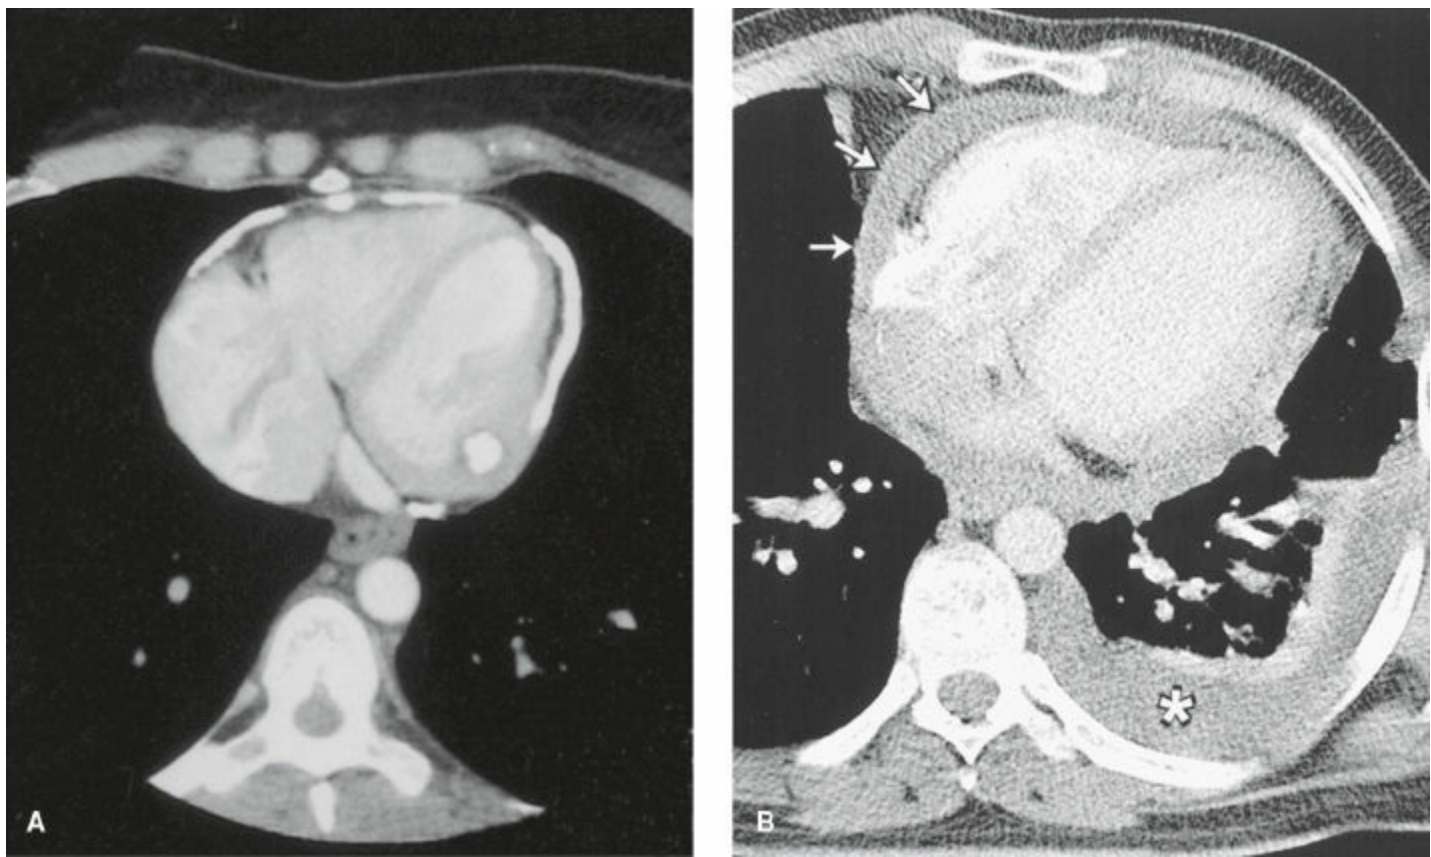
A: Chest CT shows extensive pericardial calcification. (From Cavendish JJ, Linz PE. Constrictive pericarditis from a severely calcified pericardium. *Circulation* 2005;112(11):e137–e139, with permission.) B: Chest CT shows thickening of the pericardium in a patient with constrictive pericarditis. (From Tom CW, Oh JK. A case of transient constrictive pericarditis. *Circulation* 2005;111:e364, with permission.).
